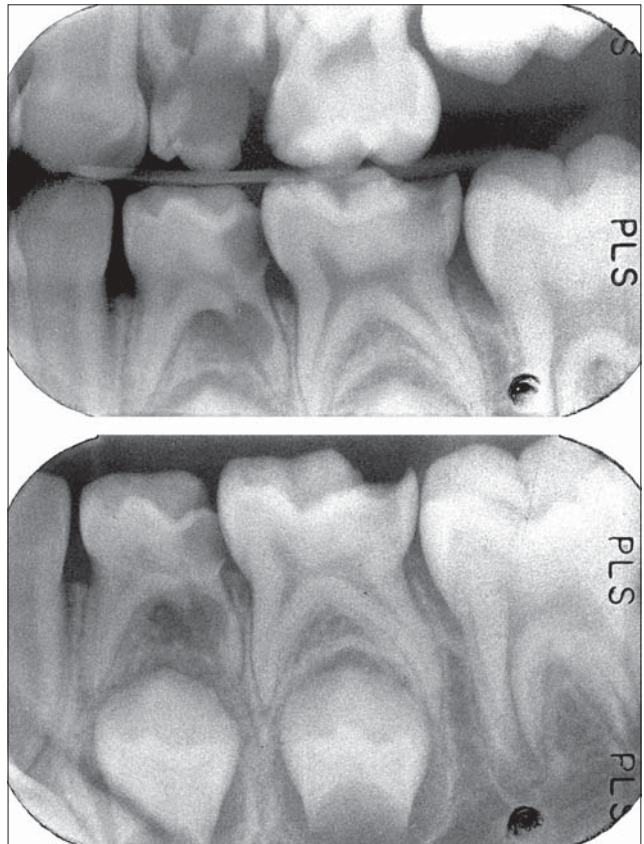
Case B; preoperative radiographs of an asymptomatic mandibular left second primary molar with deep carious dentin.
